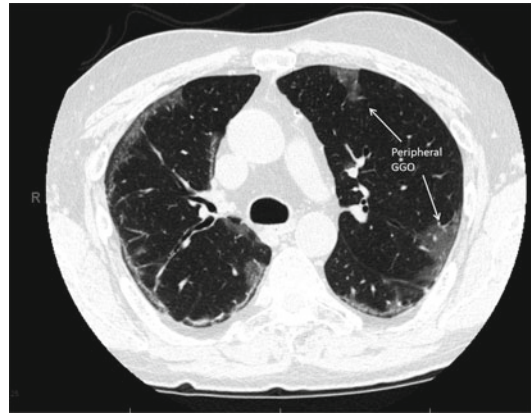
Computed tomography of bronchiolitis obliterans organizing pneumonia (BOOP), with presence of peripheral ground-glass opacification (GGO, arrows). Reprinted with permission from Current opinions in oncology. 2013, Vol 25:187–194, Walters Kluwer Health. Lippincott Williams and Wilkins
